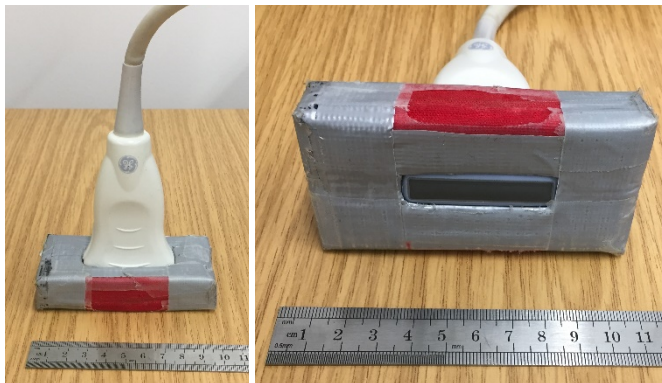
Ultrasound probe transducer with a probe holder frame.
